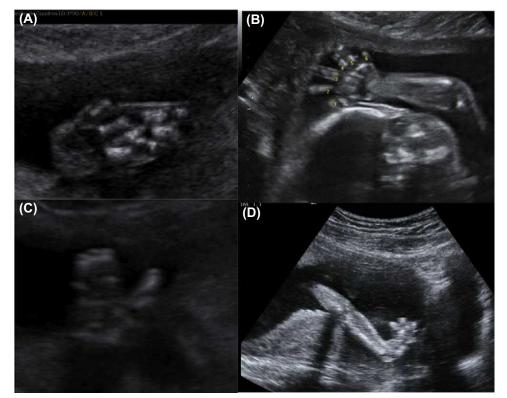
A variety of congenital differences diagnosed by ultrasound at 21 weeks of gestational age: (A) complex syndactyly, (B) postaxial polydactyly, (C) ulnar deficiency with oligosyndactyly, and (D) radial clubhand with absent radius.
